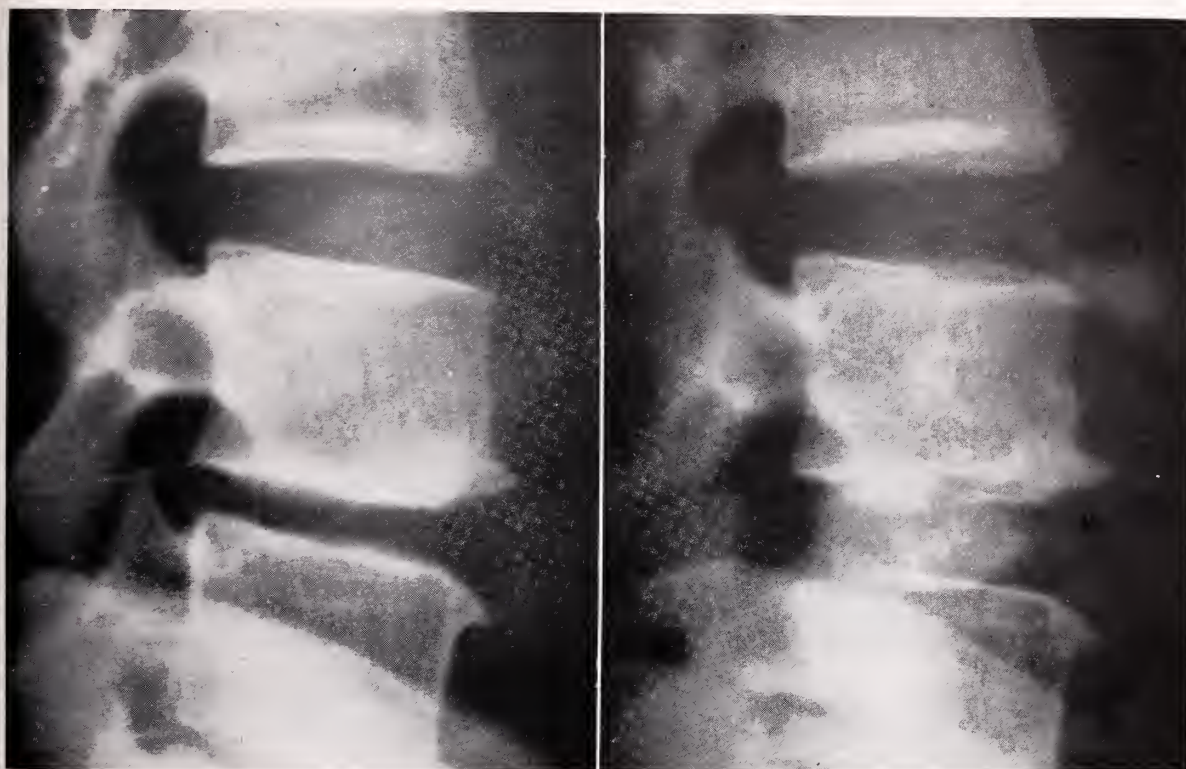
Ruptured disc at L4-5, of one year's duration. a. Note narrow intervertebral space, small intervertebral foramen and local osteophyte formation. b. Post-operative x-ray after removal of degenerated disc and replacing with four bone plugs for vertebral body fusion. Note widened intervertebral space.
